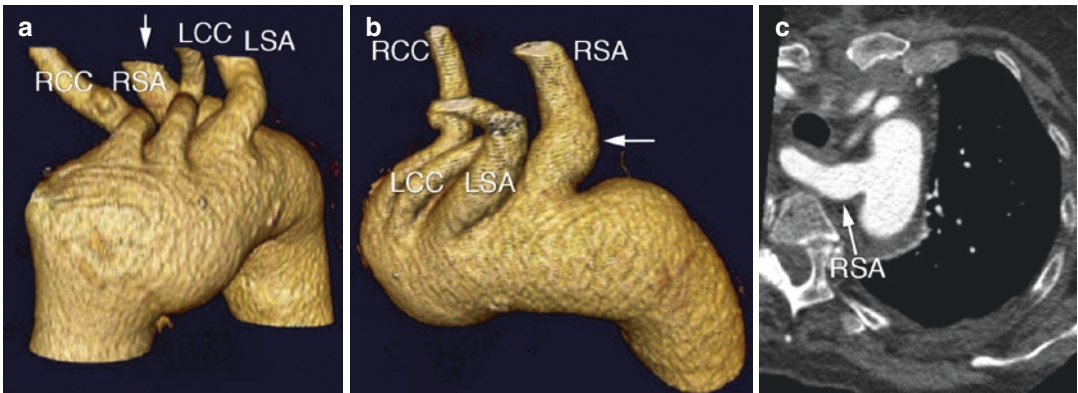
Aberrant right subclavian artery. CT angiography in a 76-year-old female patient with aortic aneurysm after ascending aorta replacement. Aberrant right subclavian artery (RSA), also called lusoria artery as incidental finding (arrow a and b). The RSA artery arises as the last
